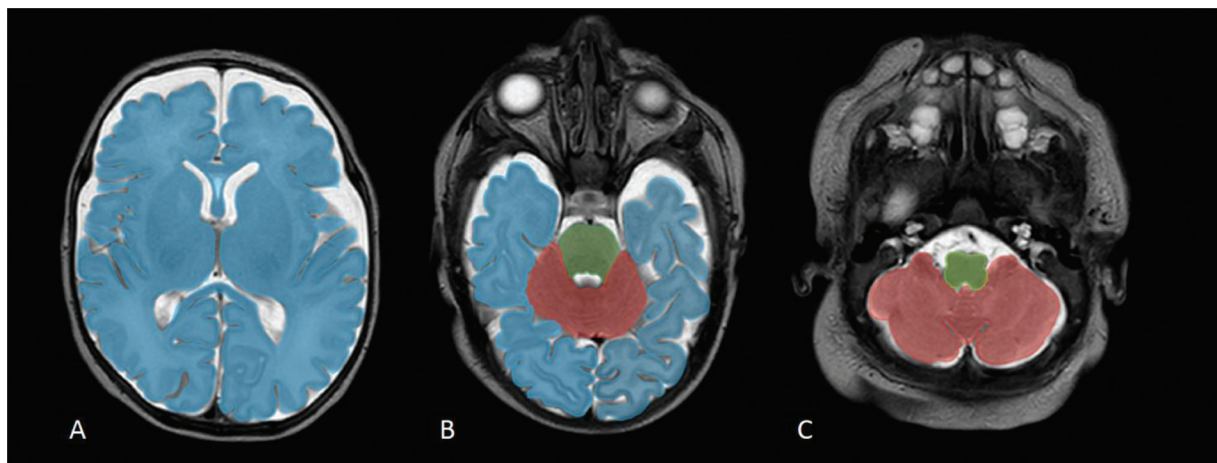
Volumetric measurements, T2-weighted axial MR images. Supratentorial volume is shown in blue-shaded areas (A, B); cerebellar volume is shown in red-shaded areas (B, C); brainstem volume is shown in green-shaded areas (B, C).
